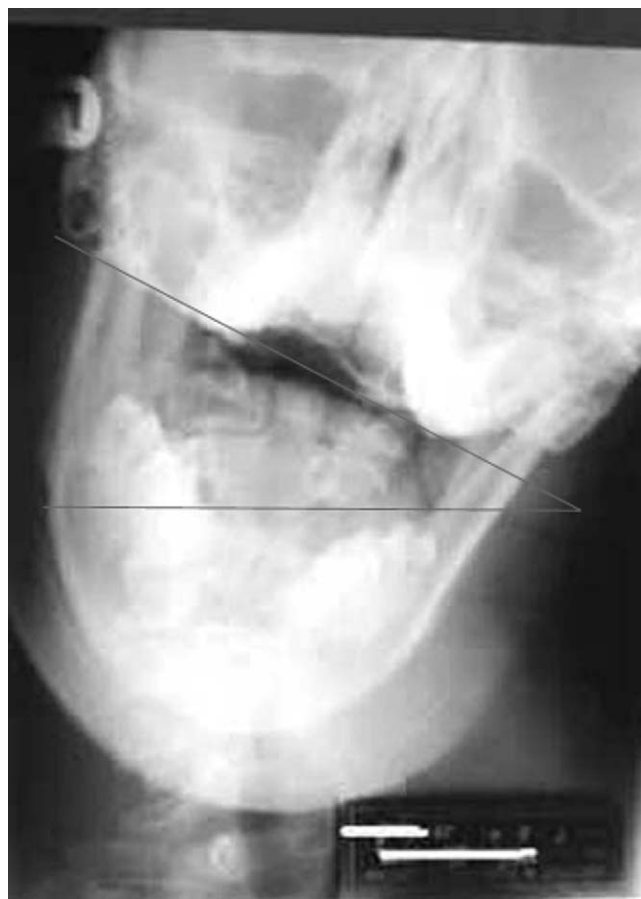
APOM radiograph showing lateral deviation of the upper cervical spine.
